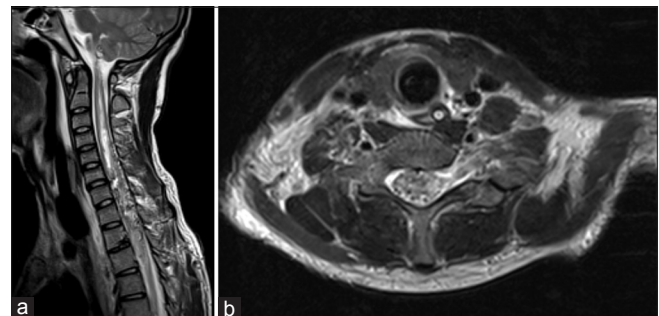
(a) Sagittal cervicodorsal T2-weighted MRI revealing the AVM from C5-D2, with multiple flow voids compromising the whole thickness of the spine and severe intensity changes up to well above in the first cervical spinal segment. (b) Axial plane T2-weighted MRI at the level of C7
